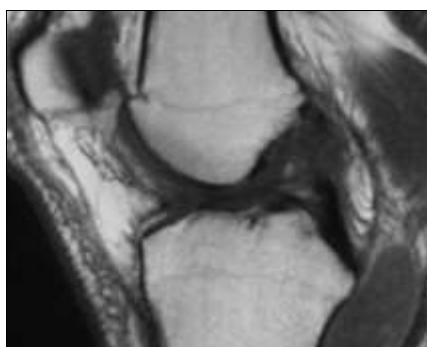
MRI view of complete tear of ACL Fig 3: Arthroscopic view of complete tear of ACL
